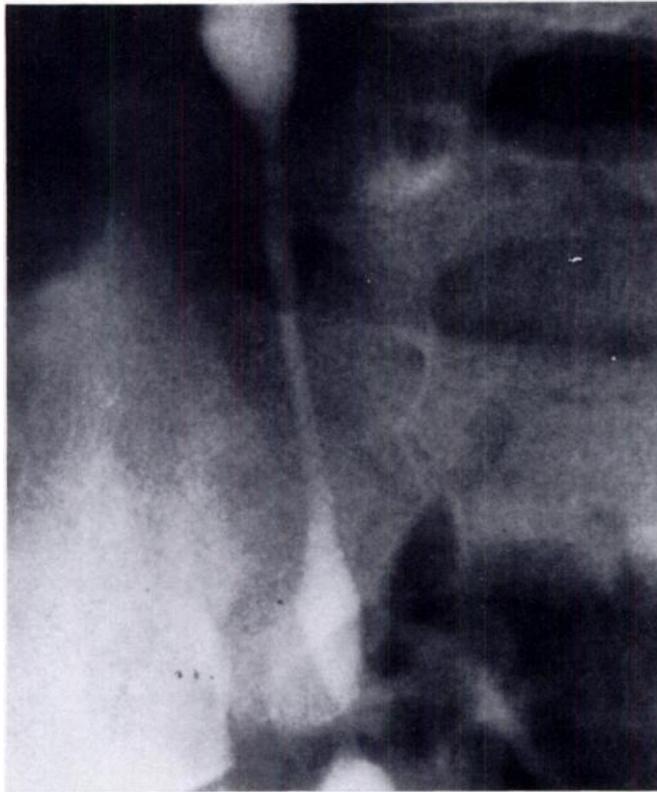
Case 2, 7-year-old boy with left-to-right ureteroureterostomy and placement of a tapered ileal conduit connecting upper urinary tracts to bladder with an antireflux procedure performed 3 years earlier. A, Excretory urogram. Bilateral hydronephrosis unchanged from radiographs 8 months earlier. Urogram 9 months after A demonstrated increased hydronephrosis. B, Retrograde pyelogram. Probable right ileoureteral obstruction (arrow). C, Antegrade pyelogram obtained at the time of Whitaker procedure. Chiba needles in both right and left renal pelvis. Ureteroureterostomy is patent. Right ileoureteral obstruction. D, Close-up of patent ureteroureterostomy. E, Close-up of right ileoureteral obstruction.
